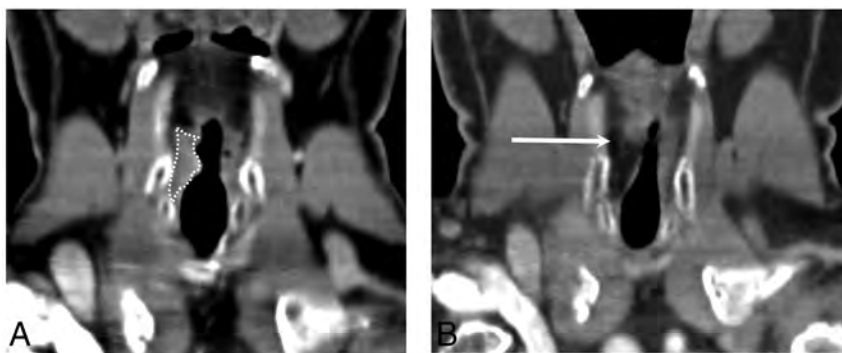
Autologous fat. A, Coronal CT at the level of the vocal folds demonstrates transglottic carcinoma on the right (white dotted line). B, Coronal CT posttreatment shows low-attenuation material within the right vocal fold status post fat augmentation (arrow).
